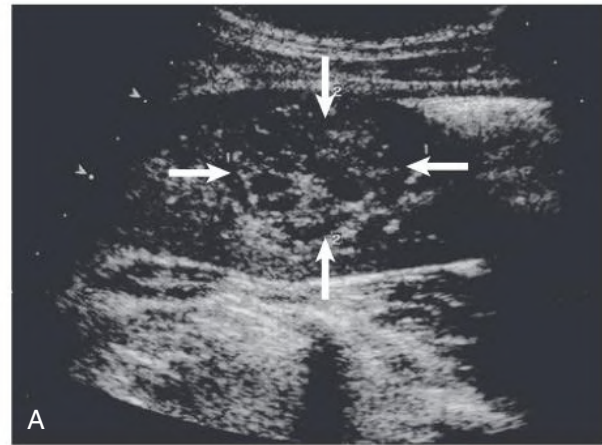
Contrast Ultrasonography. (A) Sagittal kidney ultrasound image with a large, central kidney cell carcinoma (*arrows*). (B) Central carcinoma better seen after injection of contrast material. (Courtesy Dr. Christoph F. Dietrich.)
